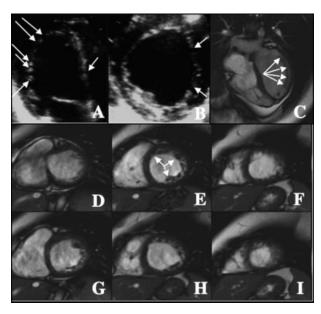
Echocardiographic study (A: apical four-chamber view; B: parasternal short-axis view) showing the marked trabeculation of the left ventricle of the proband (III:10). Cardiac magnetic resonance study (C-I) confirmed and better highlighted (C, E; arrows) the trabeculation pattern.
